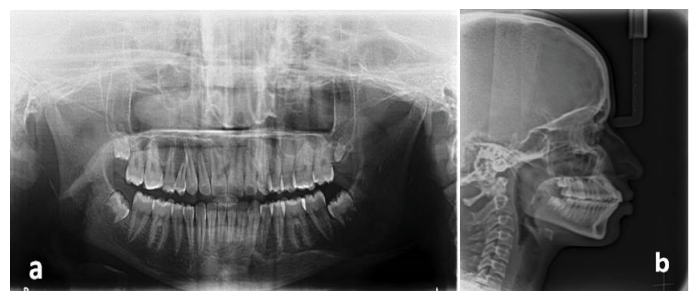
(a) Post-treatment orthopantomograph; (b) Post treatment lateral cephalography.
